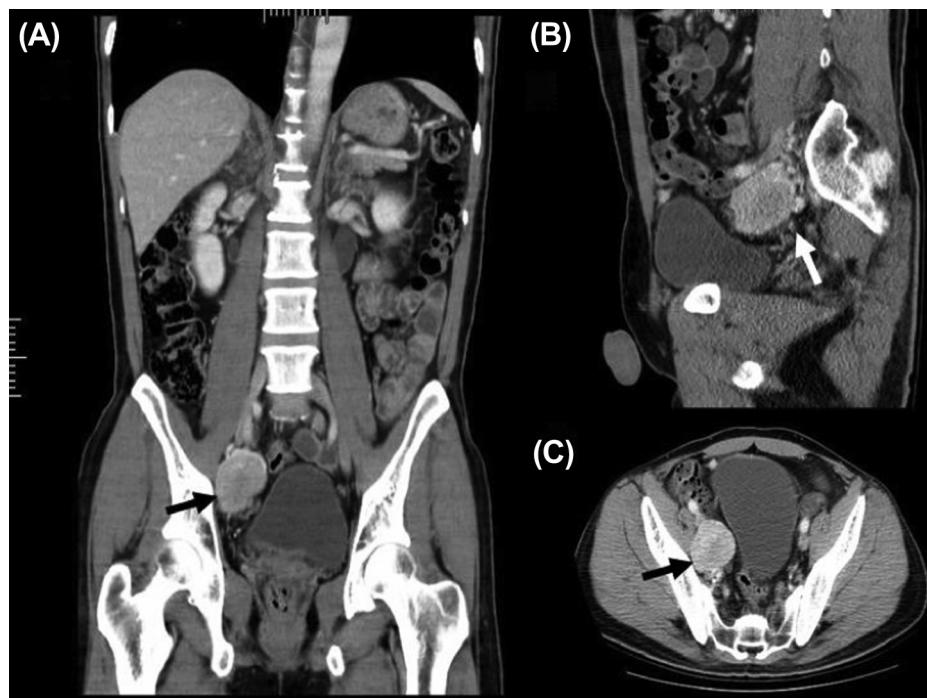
Biphase computed tomography revealed a 4.2 cm × 3.9 cm × 4.0 cm round, well-defined and enhanced mass at the right pelvic region beside the urinary bladder (arrow): (A) coronal view; (B) sagittal view; (C) transverse view. There was no connection between them.
